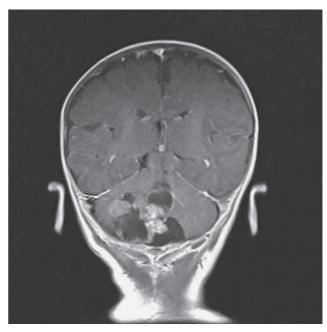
Brain MRI scan showing a mass originating from the fourth ventricle, later identified to be an ependymoma (coronal T1 weighted sequences after intravenous contrast)
